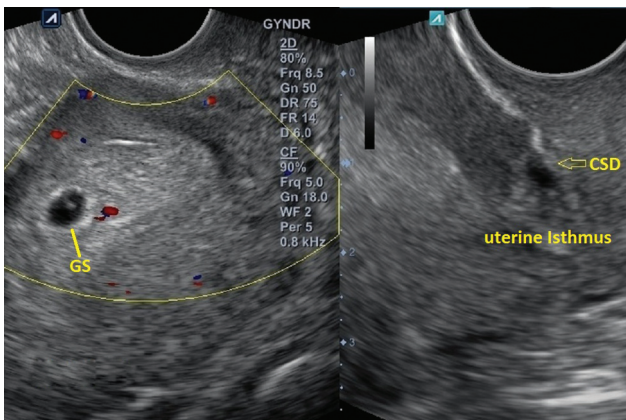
TVUS reveals a 5-week intrauterine gestational sac with an isthmocele (arrow). The RMT/AMT ratio was <50%. In such cases, the risk of PAS increases if the future placenta is anterior and low lying. The niche can retain POC in the event of spontaneous abortion or if MTP is chosen. AMT, adjacent myometrial thickness; CSD, cesarean scar defect; GS, gestational sac; MTP, medical termination of pregnancy; PAS, placenta accreta spectrum; POC, products of conception; RMT, residual myometrial thickness; TVUS, transvaginal ultrasound.
